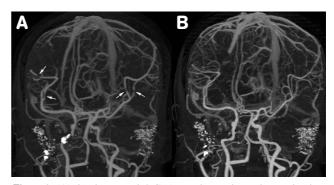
(A) 3D intracranial CTA maximum intensity projection (MIP) technique in different projections shows multifocal segmental vessels luminal stenosis (arrows) but still preserves normal antegrade flow at bilateral M.C.A M2-M3 segments. (B) A follow-up CT angiography 3-4 months later shows no more intracranial focal vessels stenosis or spasm for this reversible cerebral vasoconstriction syndrome patient.
